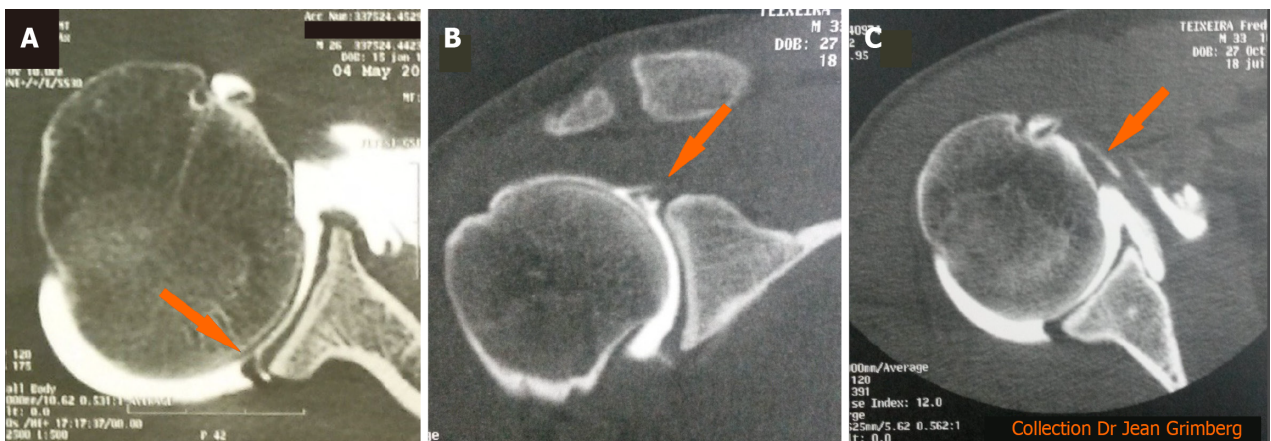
Computed tomography arthrography is useful in cases of false-negative magnetic resonance imaging results. A: Posterior labral tear on the sagittal view; B: Superior labral anterior posterior lesions are best detected on the coronal view; C: Computed tomography arthrogram is the modality of choice in cases of undetected subscapular tears. The sagittal view showed widening of the bicipital canal, which is an indirect sign of subscapularis rupture and delamination with penetration of contrast fluid into the tendon (orange arrow).
